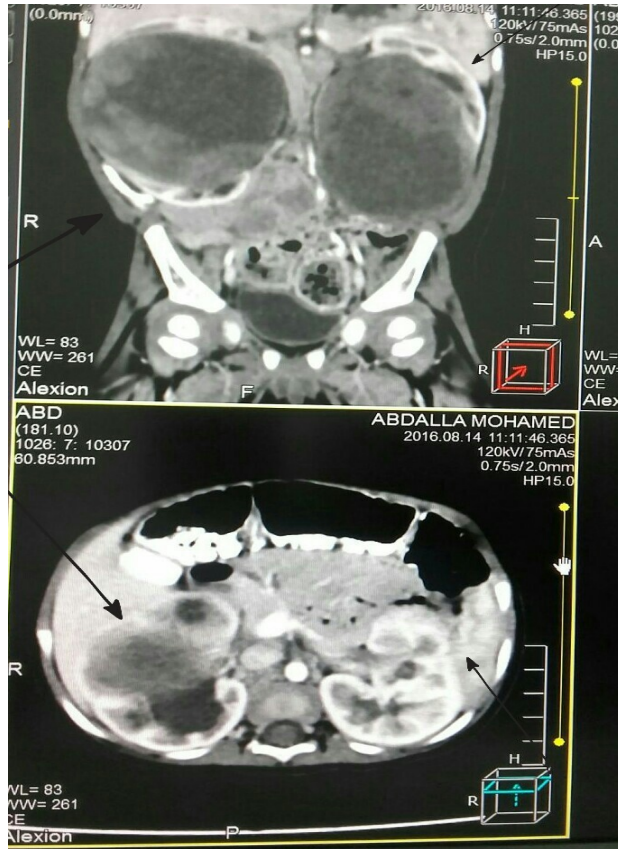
CT pelvis axial and sagittal for Patient 13years has renal .(cell carcinoma (black arrow
